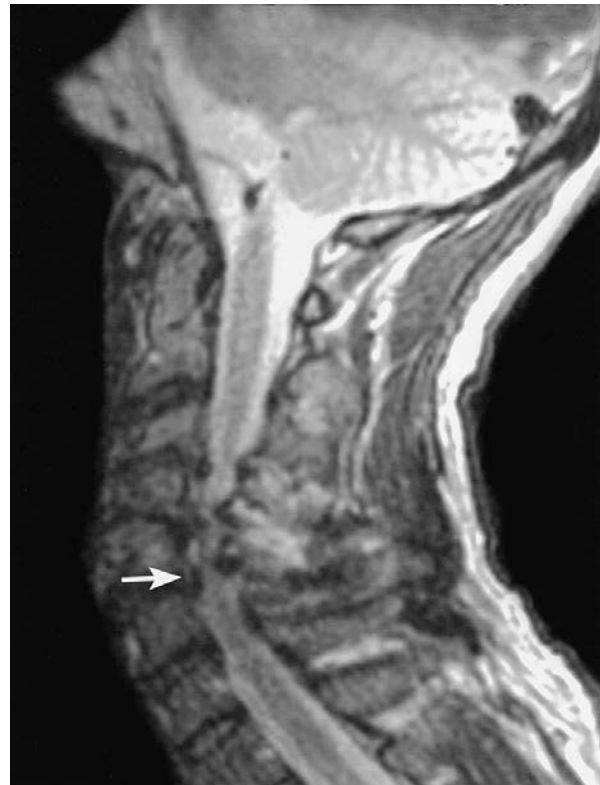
MR image from an adult with extrapyramidal CP, who sustained cord compression (white arrow) from repetitive head movements used to control a communication system.
